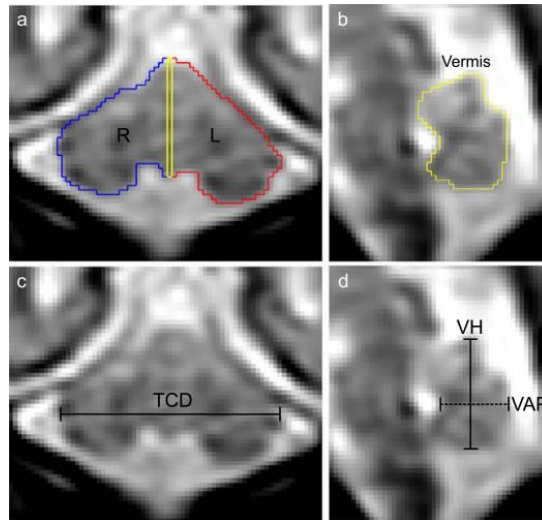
Describe The linear measurement of cerebellum in MRI
